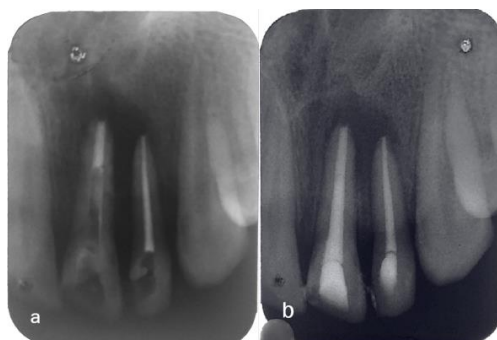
(a) shows intra-operative radiograph, obturation w.r.t 22 was done and MTA plug was placed w.r.t 21, (b) obturation i.r.t 21 completed after 48 hours.
